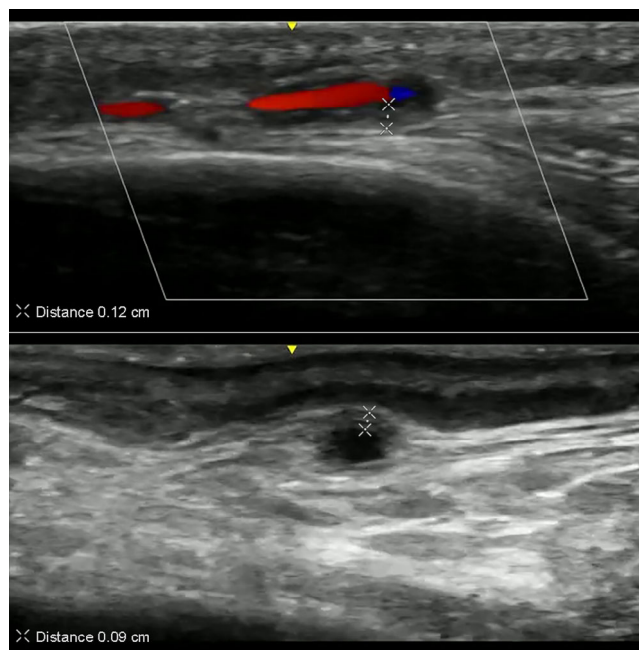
Point of care ultrasound examination of the right temporal artery.
